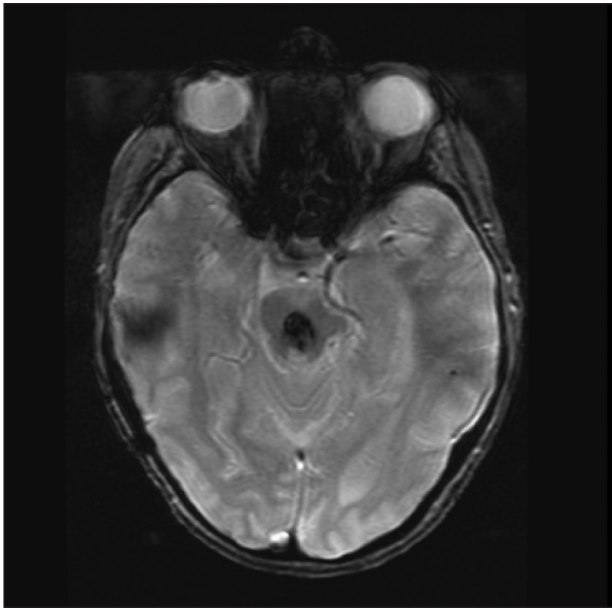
T2-weighted gradient-echo, magnetic resonance imaging (MRI) shows a midbrain cavernous malformation.
